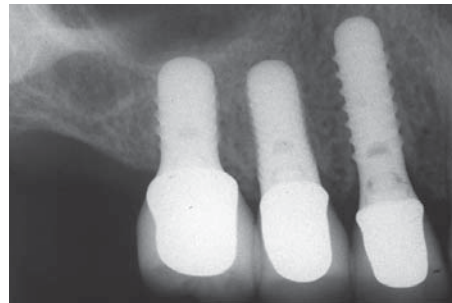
A radiograph taken eight years posttherapy demonstrates stability of the peri-implant crestal bone.
